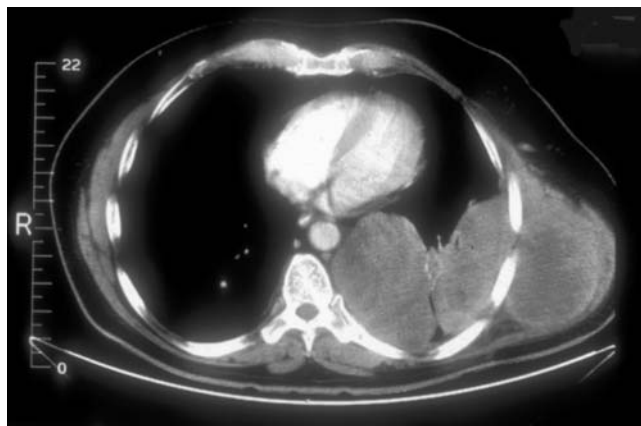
Chest computed tomographic scan reveals a large pulmonary and chest wall mass.
